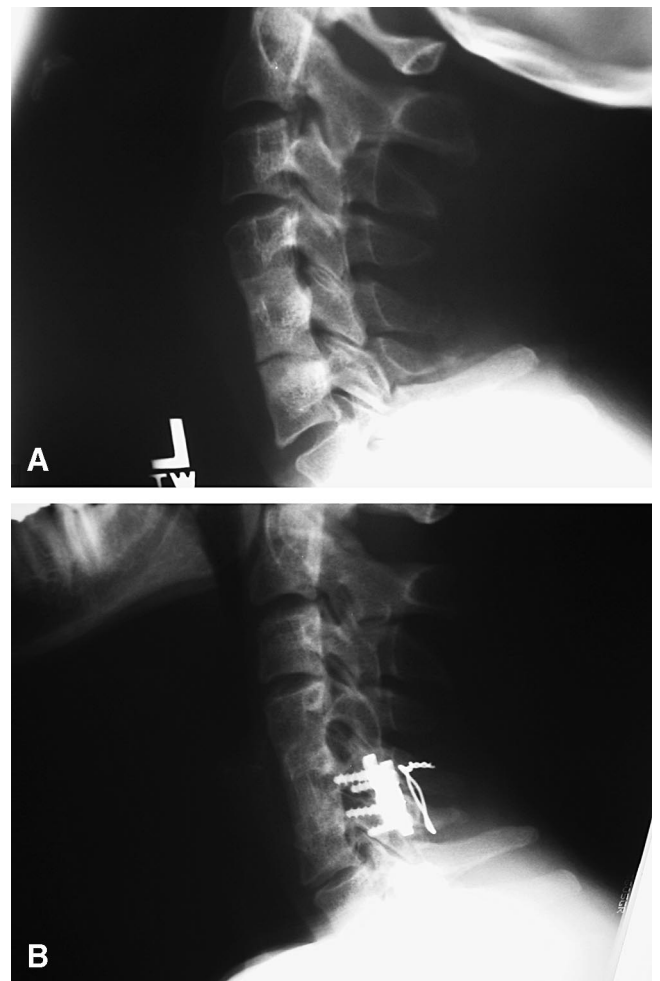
A, Preoperative lateral radiograph of pseudarthrosis at C5–C6 after previous C4–C5, C5–C6 ACDF. B, Lateral radiograph after posterior procedure demonstrating fusion at C5–C6.
